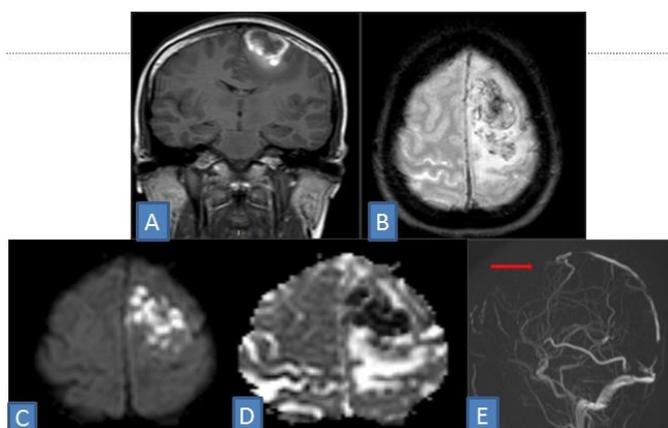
Venous hemorrhagic infarct in left frontal lobe due to superior sagittal sinus thrombosis appearing hyperintense on Coronal T1W images(A) , showing blooming on GRE (B) , restriction on DWI (C) and loss of signal on ADC (D) images . The 3D Venogram image (E) reveals thrombosis of superior sagittal sinus.
